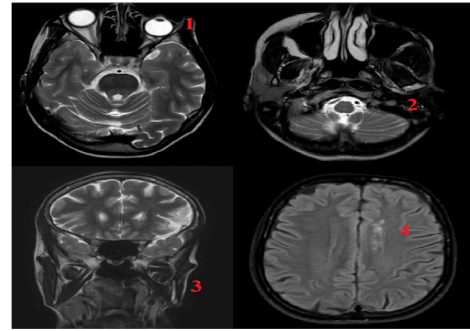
Brain MRI of the 43-years old female patient with Parry-Romberg syndrome. 1: enophthalmos, left-eyed wasting of the intraorbital fat; 2 – left parotid gland atrophy; 3 – hypotrophy of the left m. Masseter and subcutaneous fat tissue; 3 – unspecific periventricular lesions in the brain.
